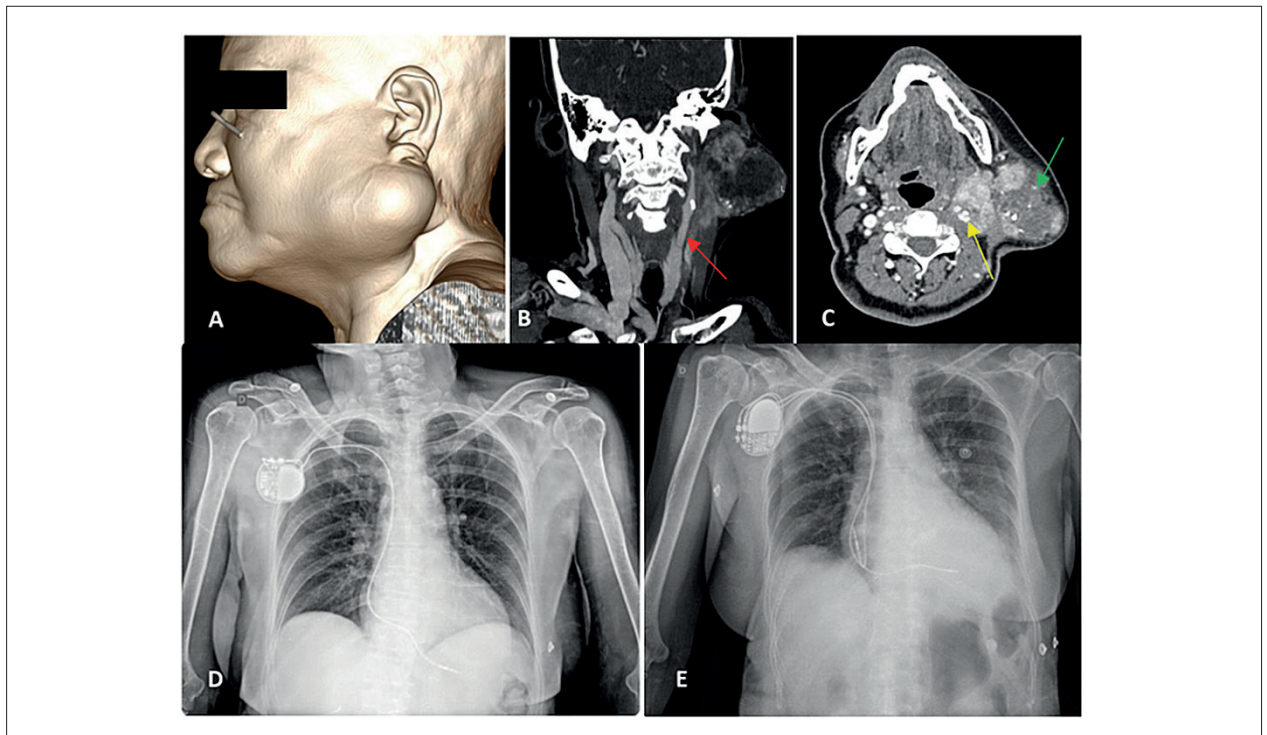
(A) Large neck mass located in the suprahyoid region, on the left. (B and C) CT-scan of the neck showing expansive formation with soft tissue density and heterogeneous enhancement, areas of necrosis, and foci of calcification (green arrow), affecting the left parotid with local bulging and involvement of the parapharyngeal space, associated with multiple lymph node enlargement. Red arrow points to the left common carotid artery and yellow arrow to the carotid bifurcation (internal and external). (D) AP chest X-ray after single-chamber PM implantation. (E) Chest X-ray with bicameral PM RDR.
